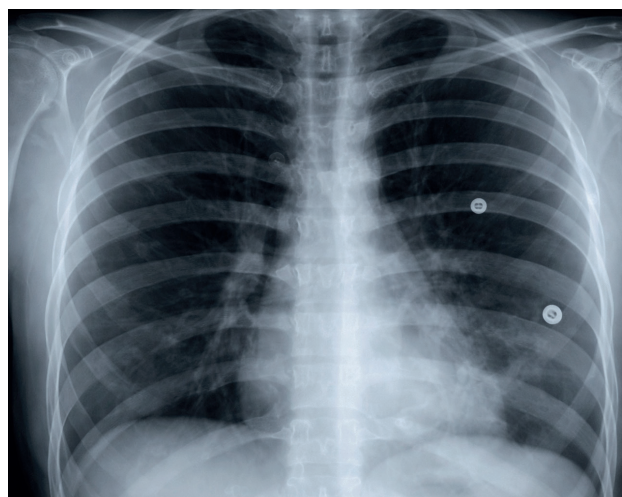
The pre-discharge control chest x-ray of case
